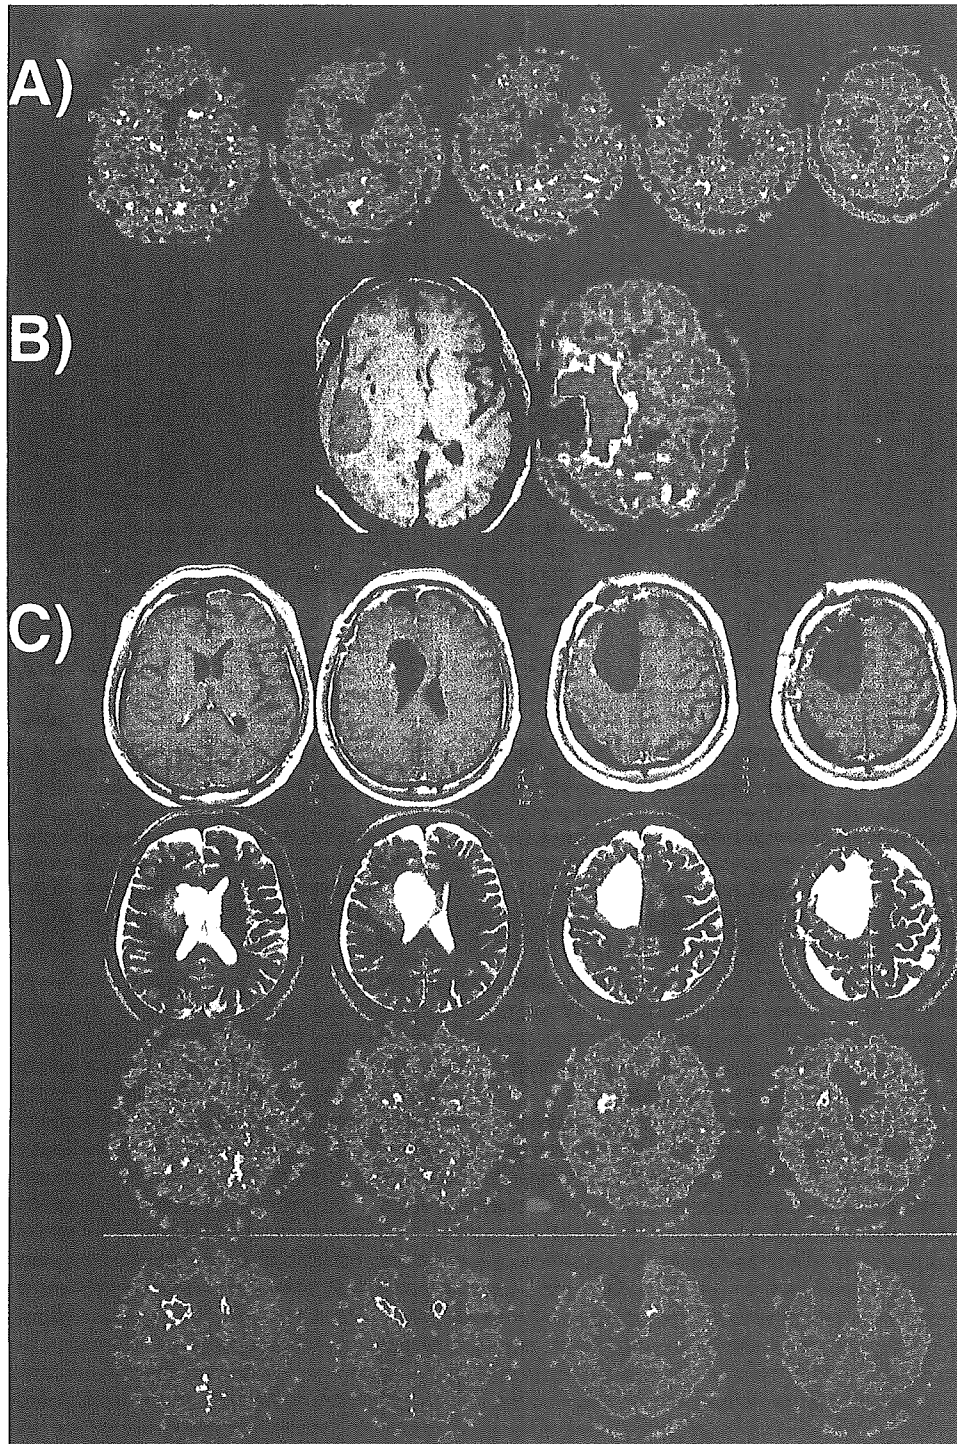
A: Postoperative MET-PET images obtained in a 42-year-old man with a left frontal GBM whose preoperative images are featured in Fig. 3. No apparent tumor remnant was detected on the MET-PET images. The patient has remained free from recurrence during the 55-month follow up since this scan. B: Postoperative Gd-enhanced T_1 -weighted (left) and MET-PET (right) images obtained in the same week in a 54-year-old woman with anaplastic astrocytoma. No apparent tumor remnant was demonstrated on the Gd-enhanced MR image, whereas the MET-PET study revealed a large tumor mass in the basal ganglia; at this time the patient was asymptomatic. Three months later, MR images revealed new enhancements in the basal ganglia and the patient demonstrated left hemiparesis. C: Postoperative Gd-enhanced T_1 -weighted MR (first row), T_2 -weighted MR (second row), and MET-PET (lower two rows) images obtained in the same week in a 46-year-old man with GBM. No apparent tumor remnant was revealed on the MR images, whereas the MET-PET images demonstrated a tumor remnant in the right basal ganglia and invasion into the contralateral frontal lobe through the corpus callosum. Gadolinium-enhanced lesions appeared in these areas 3 months later.
